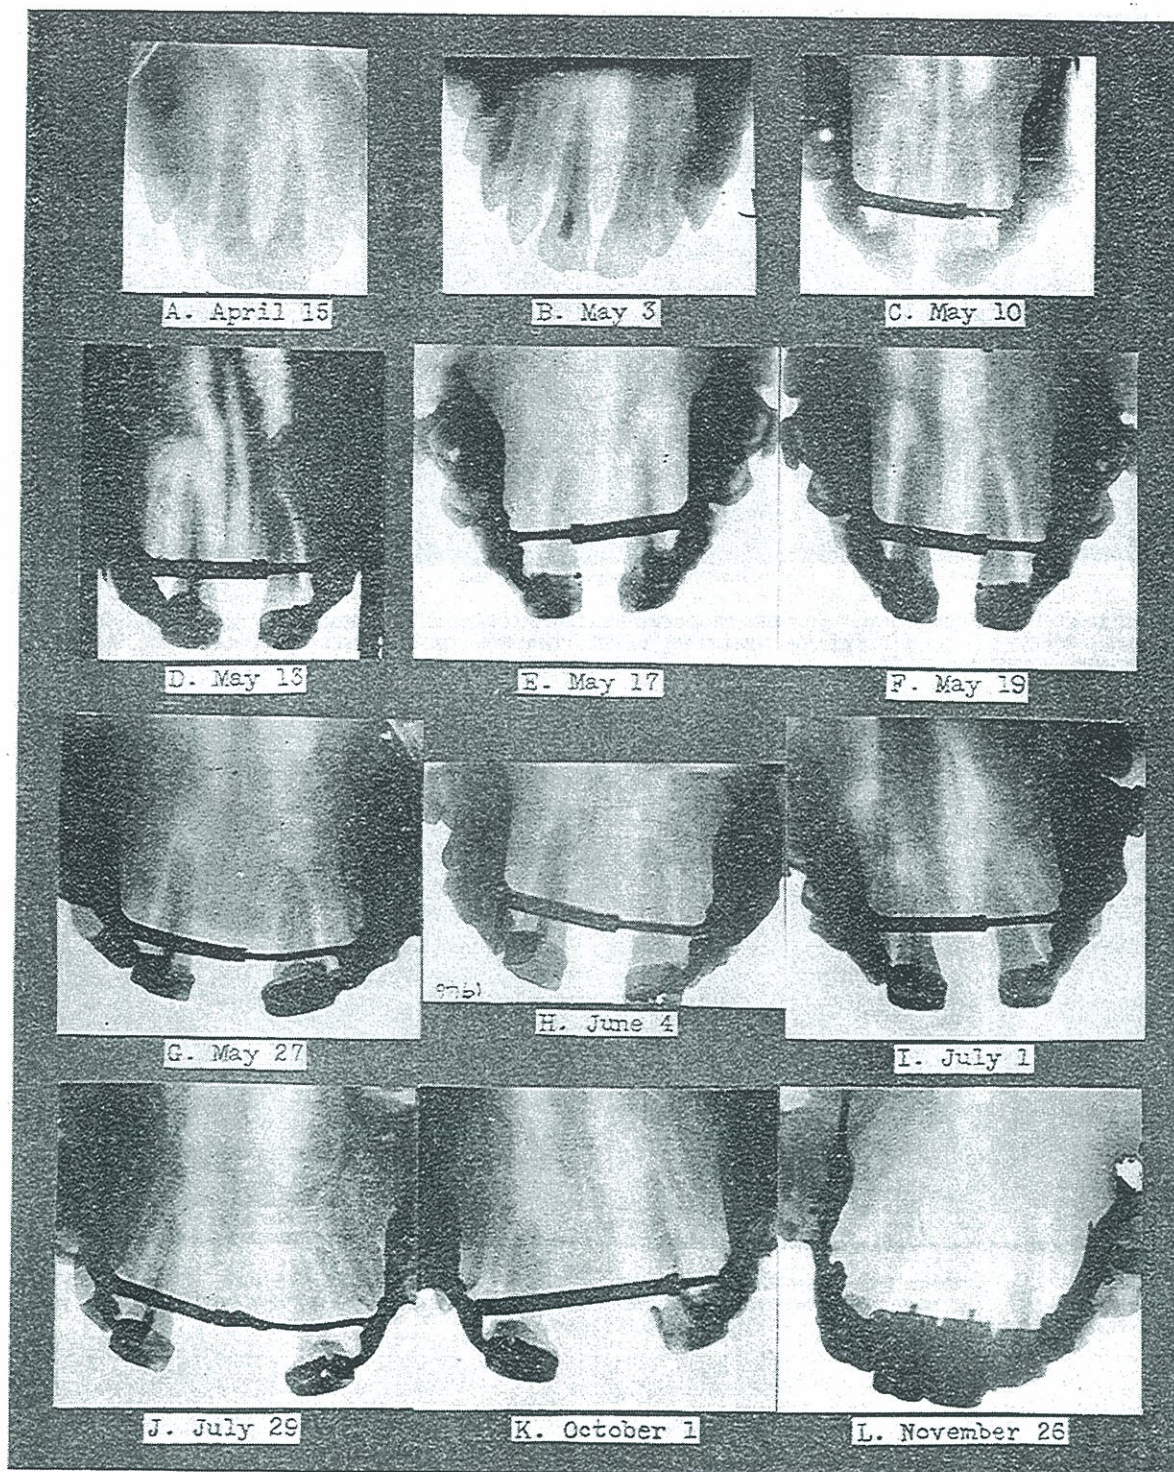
ROENTGENOGRAPHIC CHANGES BY DAYS FROM OPENING THE MEDIAN SUTURE.
